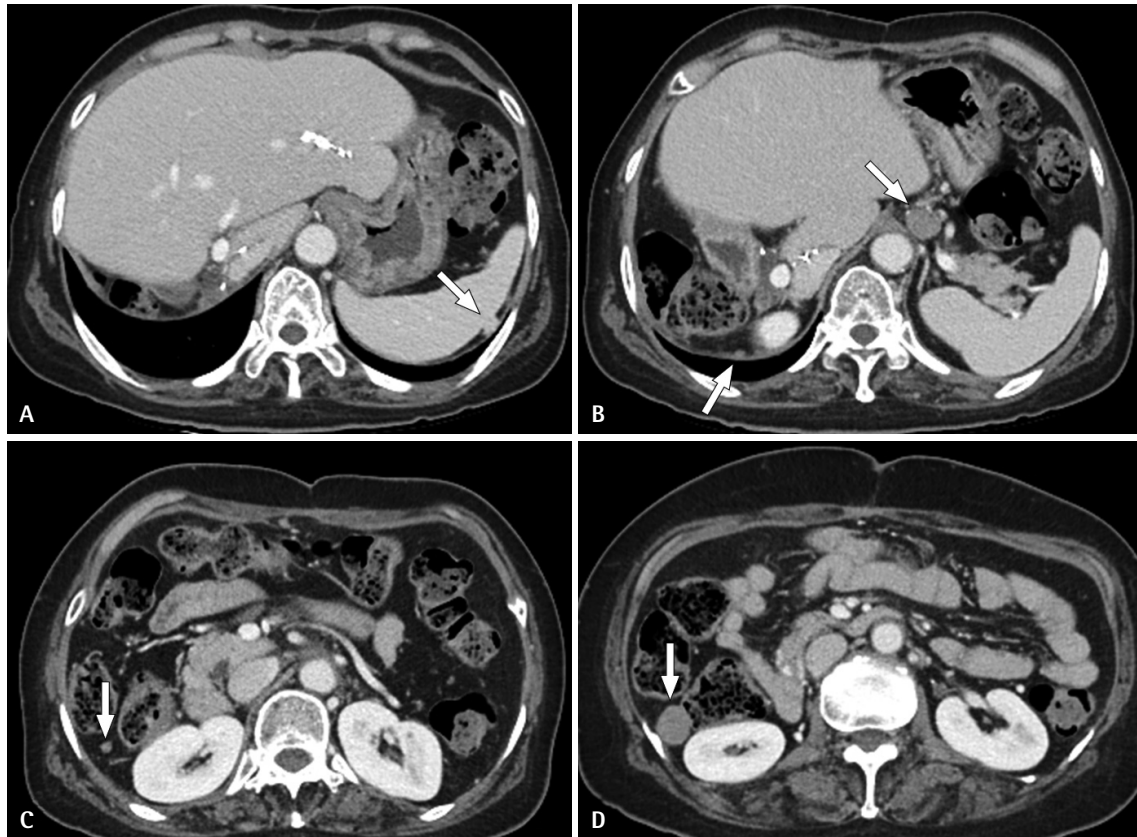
Abdominal computed tomography 15 months after hepatic resection. Multiple peritoneal seeding nodules are suspected in the peritoneal cavity (arrows): the perisplenic area (A), right subphrenic area, left gastric area (B), and along the right paracolic gutter (C, D).
